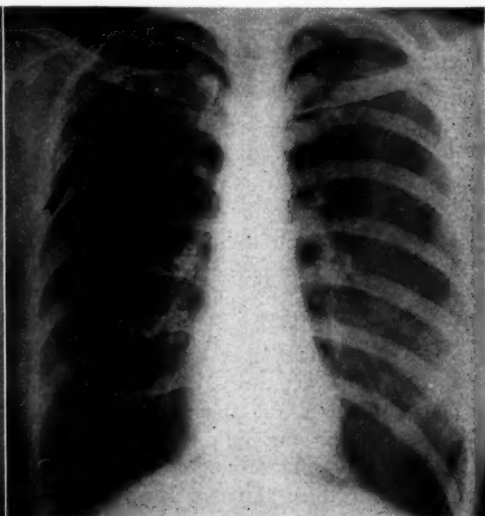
M. H. B. X-ray film of the same chest (Fig. 1) taken on November 12, 1932. Shows evidence of Ghon tubercle formation in the right second interspace. When the first infection type of tuberculosis is postponed until adult life the reaction of the body is approximately the same as when it develops in infancy or childhood.
